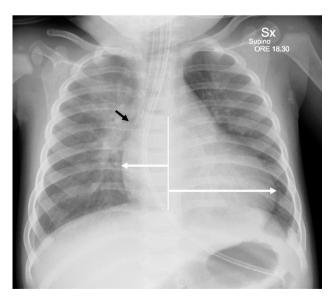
Chest X-ray, after stabilisation, shows partial resolution of alveolar oedema which revealed clearly the cardiac enlargement (white arrows). Endotracheal tube, which was distally displaced (black arrow), was promptly repositioned.
